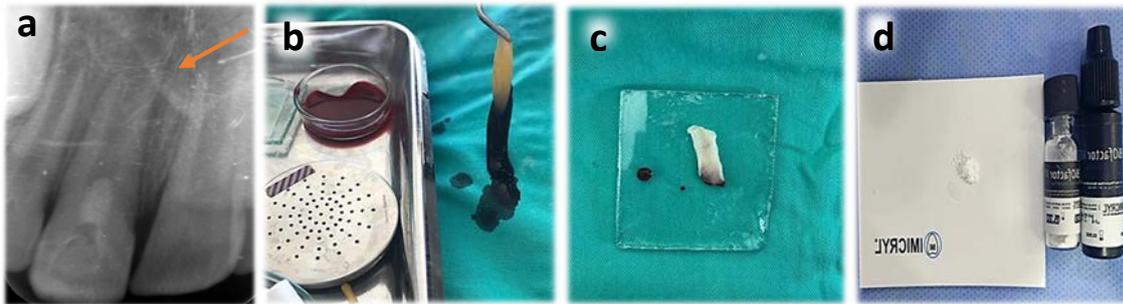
a: Last session endodontic regenerative treatment radiograph; b: Fibrin tissue obtained from the patient's blood; c: Platelet-rich fibrin; d: Mineral trioxide aggregate
